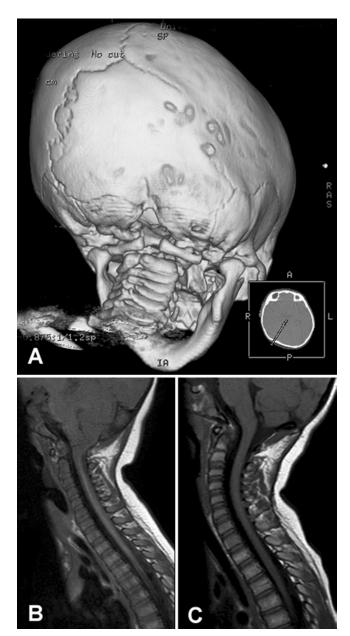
Imaging studies obtained in a 6-month-old girl presenting for evaluation of severe plagiocephaly. A: Reconstructed CT scan confirming synostosis of the right lambdoid suture. Inset: Two-dimensional depiction of the "viewing angle" that is depicted in the larger 3D image. B: Sagittal MR image demonstrating cerebellar tonsillar descent in a pegged configuration consistent with a diagnosis of CM. The patient underwent posterior cranial vault reshaping including barrel-stave osteotomies and removal of suboccipital bone at the posterior rim of the foramen magnum. The dura was not opened and posterior arch of the first cervical vertebra was not removed. C: Two-year post-operative MR image demonstrating no evidence of a CM.
